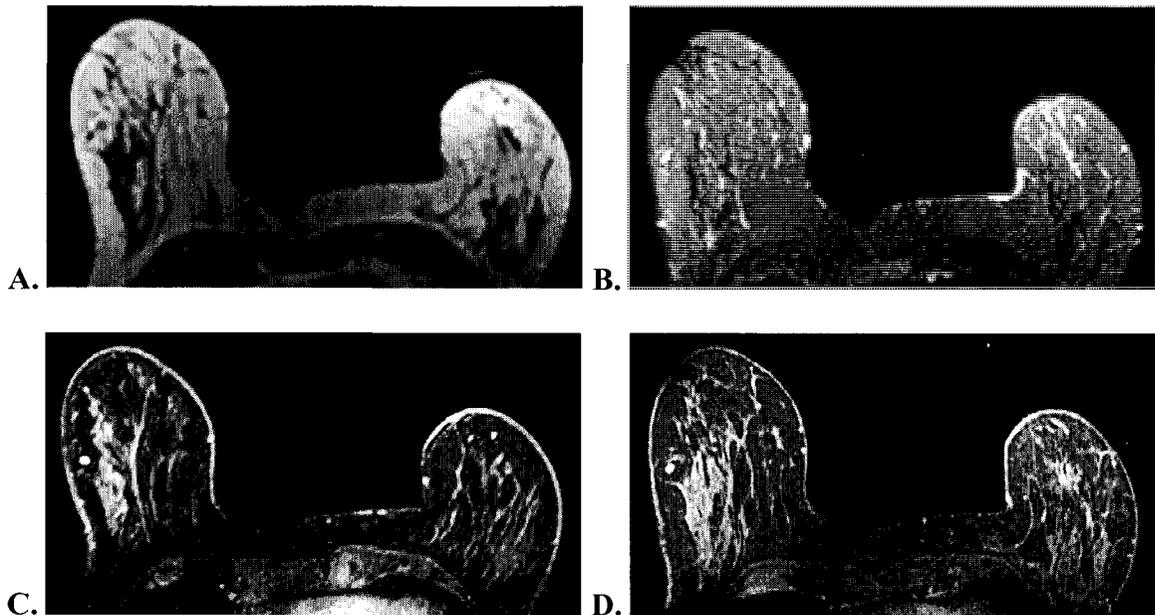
Patient 4 images from each scan performed. A) is slice 34 from the T1-weighted scan. B) is slice 34 from the T2 SPAIR scan. C) is slice 317 from the Dynamic Thrive scan. D) is slice 77 from the Thrive Post scan.
